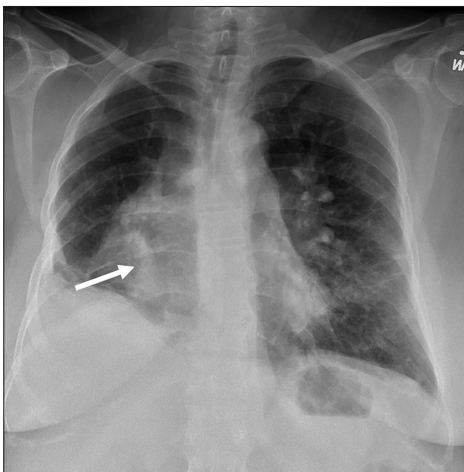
Posteroanterior chest radiograph demonstrates elevated right hemidiaphragm, mass-like opacity in the right lower zone obscuring cardiac silhouette. Furthermore, a vertically oriented linear opacity in the right lower zone was noted (arrow)
